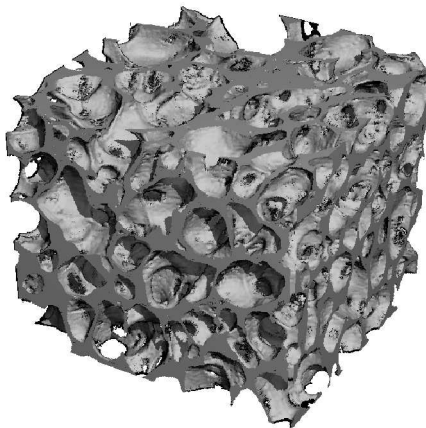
The 3D skeleton reconstructed from micro CT images of the PLLA-5% β TCP bone substitute developed at EPFL.
